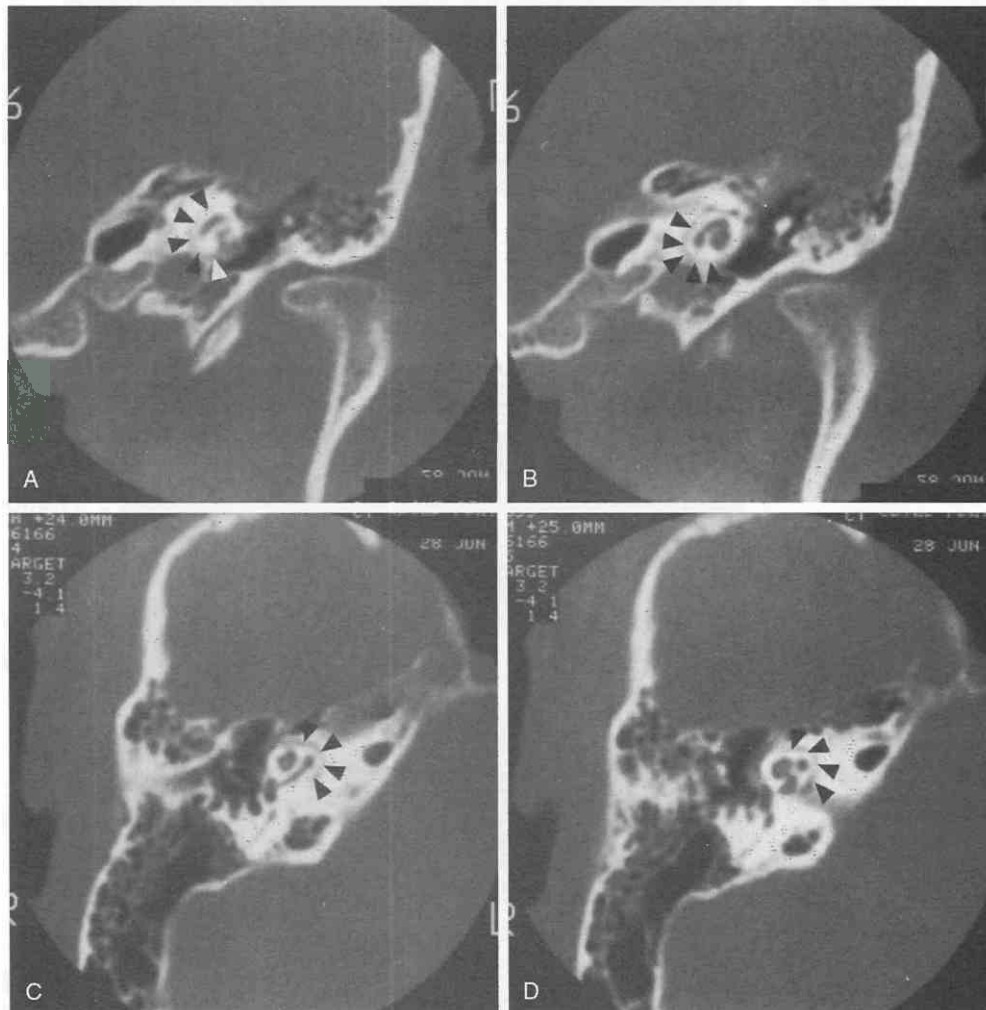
Bilateral cochlear otosclerosis in an adult with a history of progressive bilateral neurosensory hearing loss. A and B, Coronal CT scans of the left ear show a rim of hypodensity paralleling the left cochlea (*arrowheads*). This lucency represents an area of the enchondral layer of bone formation. C and D, Axial CT scans of the right ear show similar findings (*arrowheads*). (A–D, Courtesy of Dr. Galdino Valvassori.)
